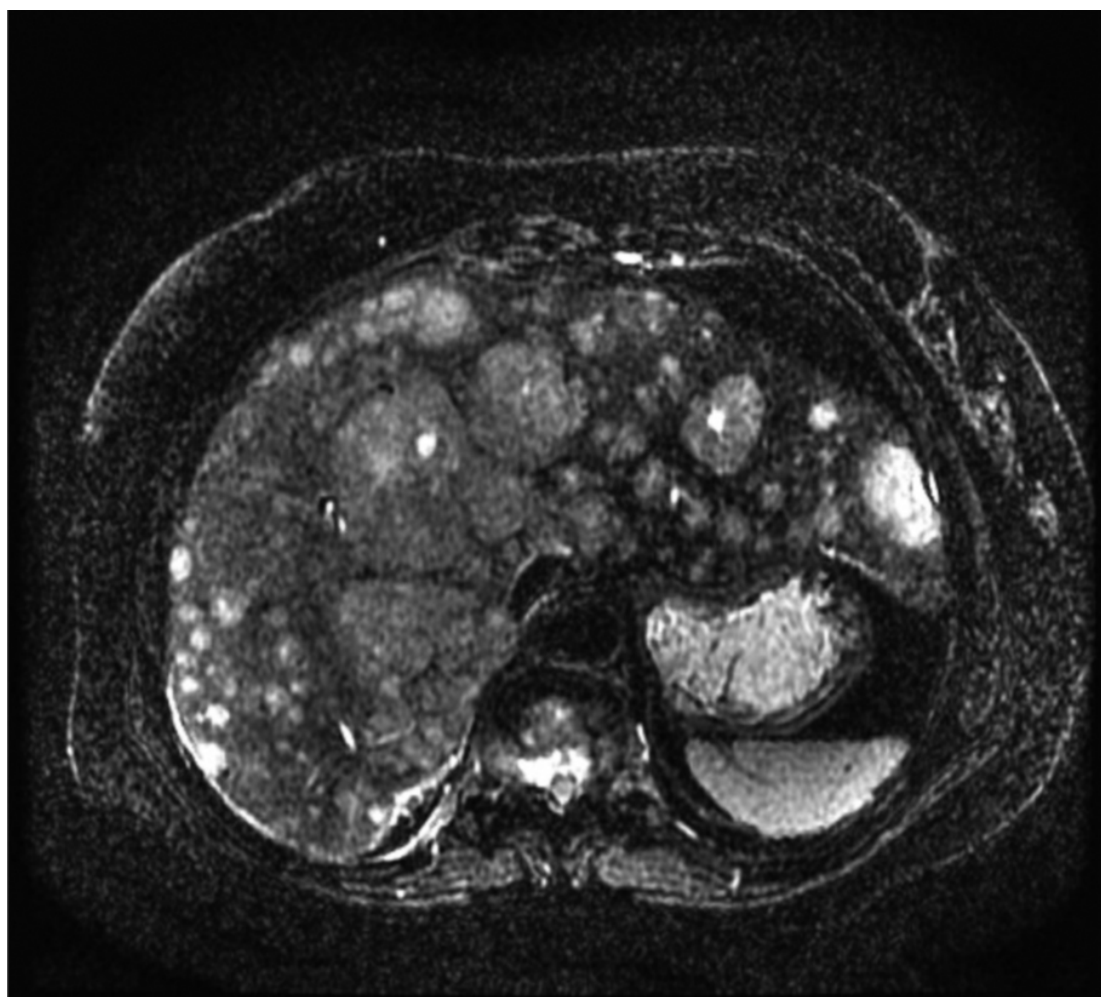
MRI scan of the progression of disease. MRI, Magnetic Resonance Imaging.
